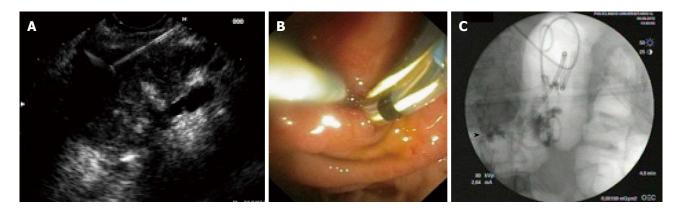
Pancreatic pseudocystis intervention. First step: Endoscopic ultrasound-guided puncture with 19-gauge dedicated needle of the pancreatic collection containing necrotic debris (A); Second step: Placement of the first plastic stent and two guidewire into the pseudocysts (PPs) for the placement of the second stent and the nasocystic drain (B); Third step: Fluoroscopic image showing the biliary stent (arrowhead), two PPs double pigtail stents and the nasocystic drain (C).
